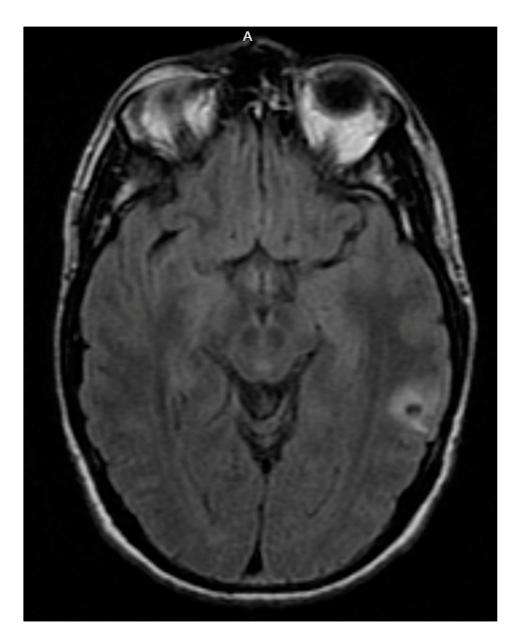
MRI brain, T2-fluid-attenuated inversion recovery (FLAIR), 2021. A 4 mm ring-enhancing lesion with halo of surrounding edema in the left posterior temporal-parietal lobe. In the clinical context of head trauma, imaging correlates with a small subacute parenchymal hemorrhage that may be post-traumatic in origin or could be related to an underlying small cavernoma.
